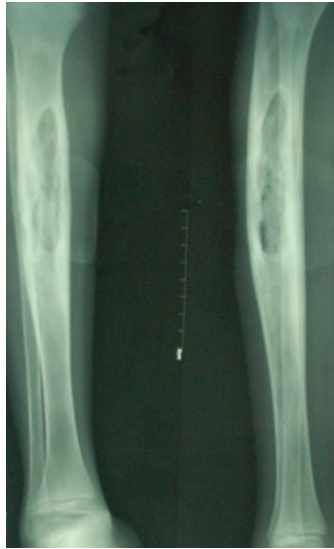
Frontal and Lateral Radiographs of the Tibia and Fibula with a Large Hypodense Lesion and a Sequestra Inside the Tibia
